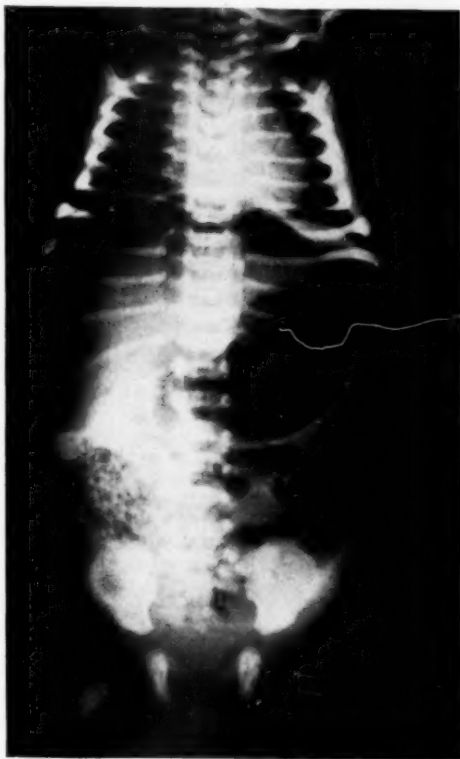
Roentgenogram of abdomen of 52-hour-old infant. A large amount of free air can be seen in the right upper quadrant extending to the left side between the liver and the diaphragm. Elsewhere there is a diffuse haziness denoting fluid within the peritoneal cavity.
